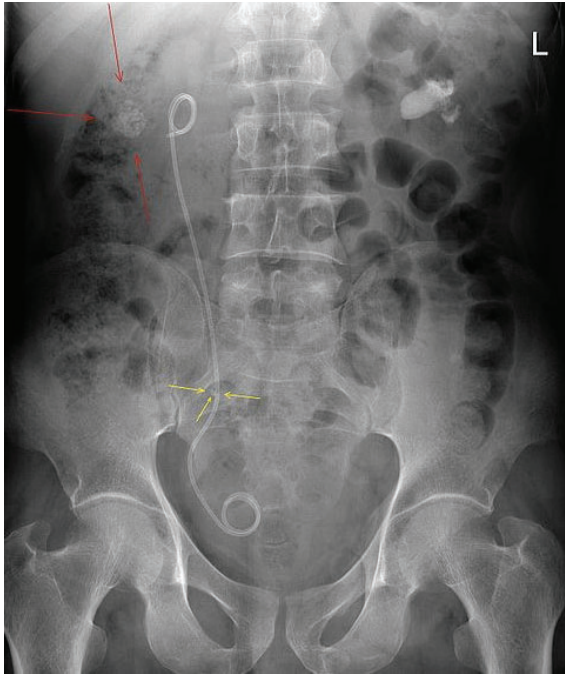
An XRay KUB with a right JJ ureteric stent, right renal stone (red) & distal ureteric stone (yellow) (Wikipedia 2008)
